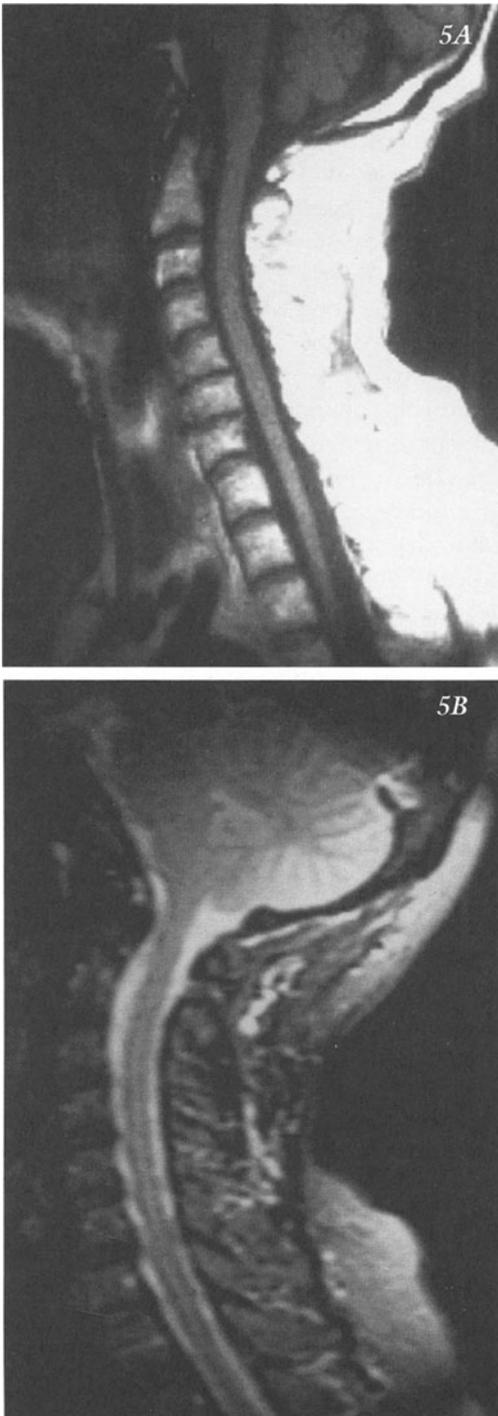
Magnetic Resonance Imaging (MRI) of the cervical and upper thoracic spine and spinal cord. A) T1 weighted B) T2 weighted from another patient; sagittal section close to midline. In both cases although degenerative disc disease is demonstrated, the spinal cord remains normal.
